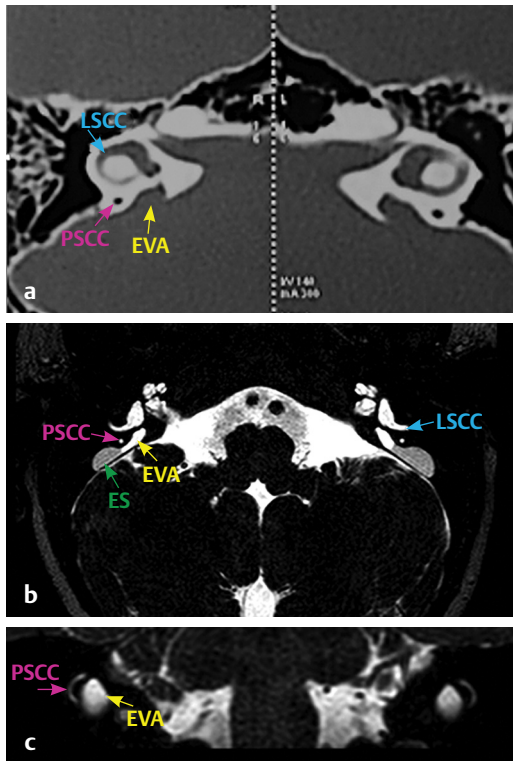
(a) HRCT temporal bone, axial section bone window and (b, c) MRI CISS sequence, axial and coronal sections show PSCC (pink arrow), LSCC (blue arrow), endolymphatic sac (ES, green arrow) and enlarged vestibular aqueduct (EVA, yellow arrow).
